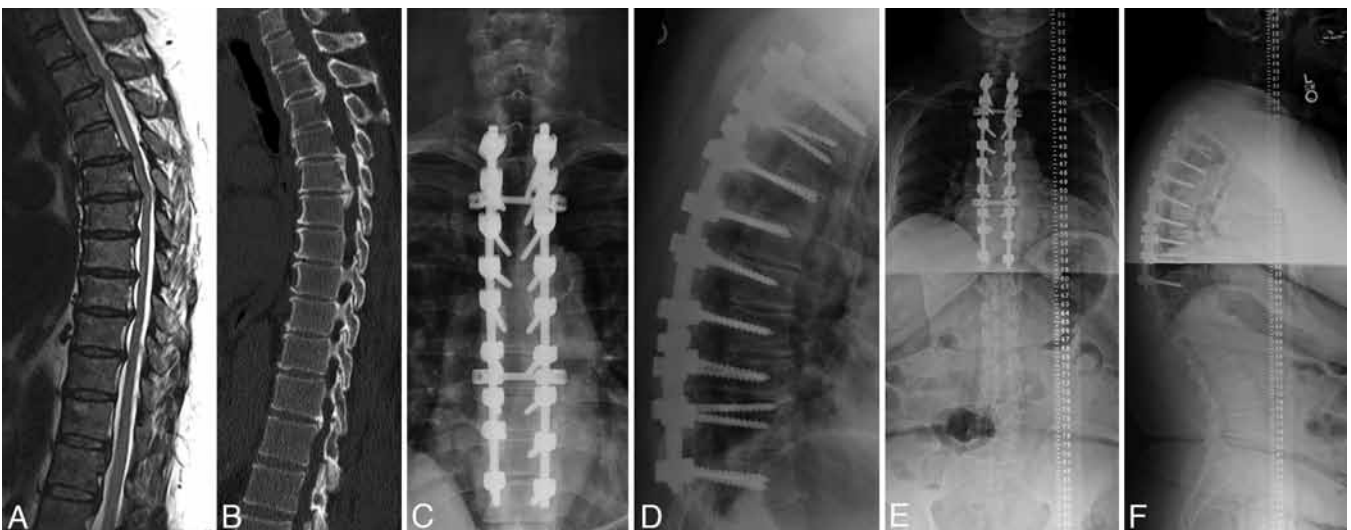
A: Preoperative T2-weighted sagittal MR image of the thoracic spine demonstrating stenosis of the spinal cord by OPLL. B: Preoperative sagittal CT scan of the thoracic spine demonstrating areas of spinal cord compression by calcified masses representing OPLL. C: Postoperative anteroposterior plain radiograph demonstrating posterior segmental instrumentation following surgical decompression. D: Postoperative lateral plain radiograph depicting segmental instrumentation and decompression for OPLL. E: Postoperative 14 × 36-in anteroposterior plain radiograph demonstrating postsurgical instrumentation. The entire cervical, thoracic, and lumbar spines can be seen in this study. F: Postoperative 14 × 36-in lateral plain radiograph depicting postoperative segmental instrumentation for thoracic OPLL.
